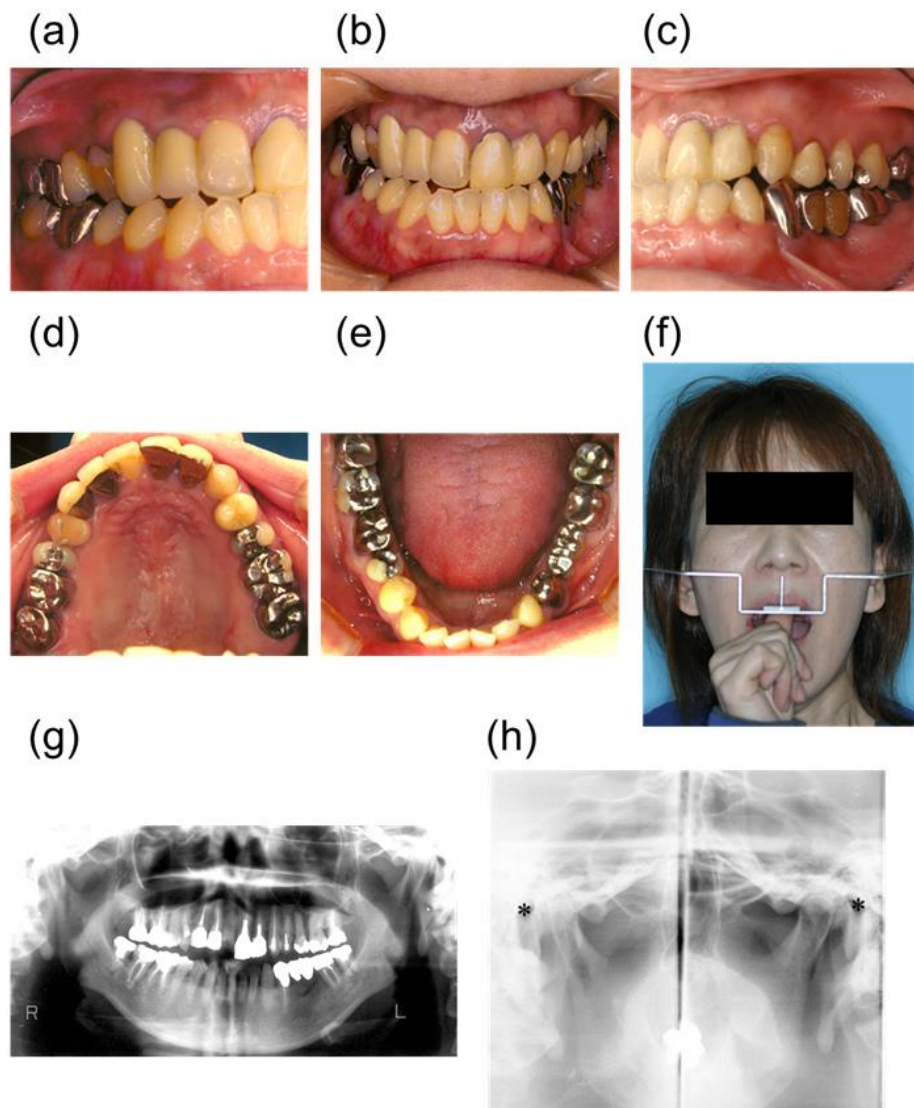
Pretreatment intra- and extra-oral photographs and radiographs at the first visit. A) Right molar relationship, B) frontal view, and C) left molar relationship in centric occlusion. D) Upper and E) lower occlusal view (flipped mirror image). F) Frontal facial photograph with an occlusal plane indicator. G) Panoramic radiograph. H) TMJ radiographs at closed mouth position. Asterisks: The external auditory foramina.
